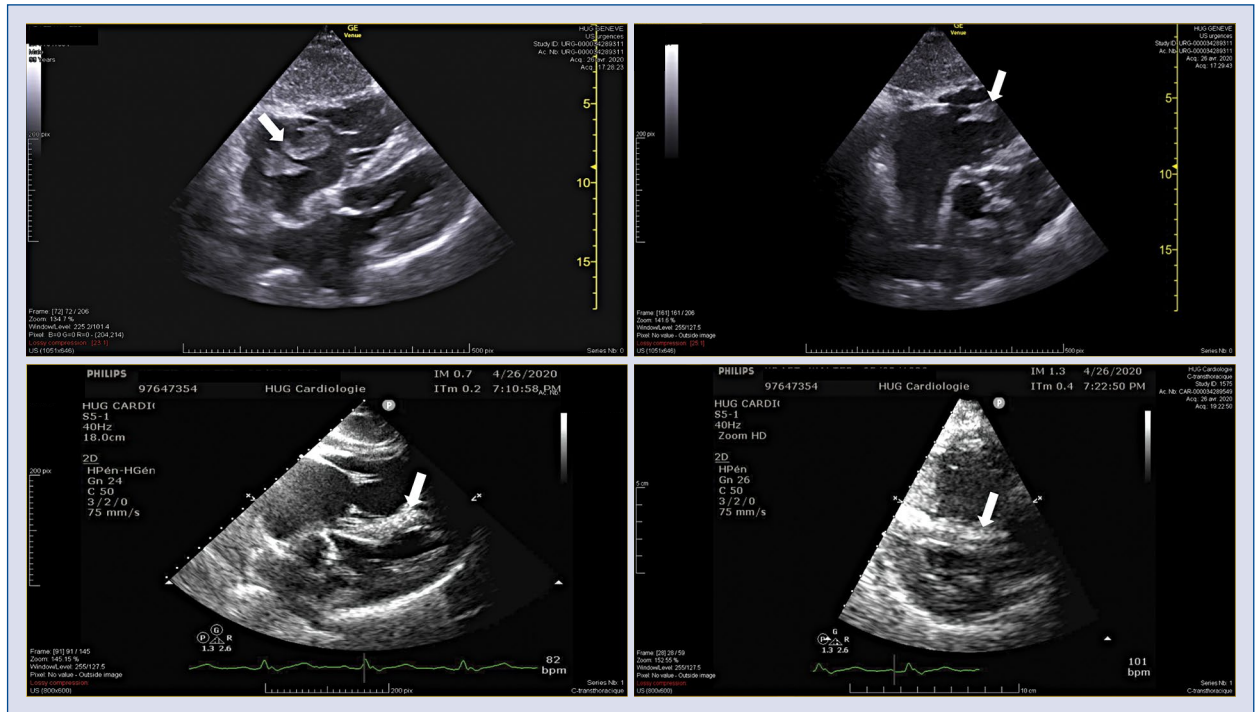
First (upper panels) and second (lower panels) focused cardiac ultrasound. Upper panels: First focused cardiac ultrasound revealing the thrombus in the right atrium (white arrow) moving in the right ventricle through the tricuspid valve (right upper panel). Lower panels: Second focused cardiac ultrasound showing the absence of the thrombus with a clear systodiastolic flattening of the interventricular septum (white arrow) in subcostal four-chamber view (left lower panel) and parasternal short-axis view (right lower panel).
